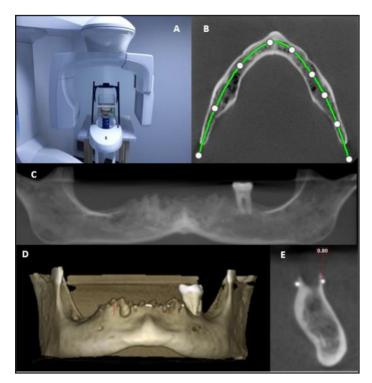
CBCT positioning and images A. Central Position, Protocol-A B. CBCT axial image panoramic curve C. Panoramic reconstruction image D. 3D CBCT scan. E. Measurement in cross-sectional section
